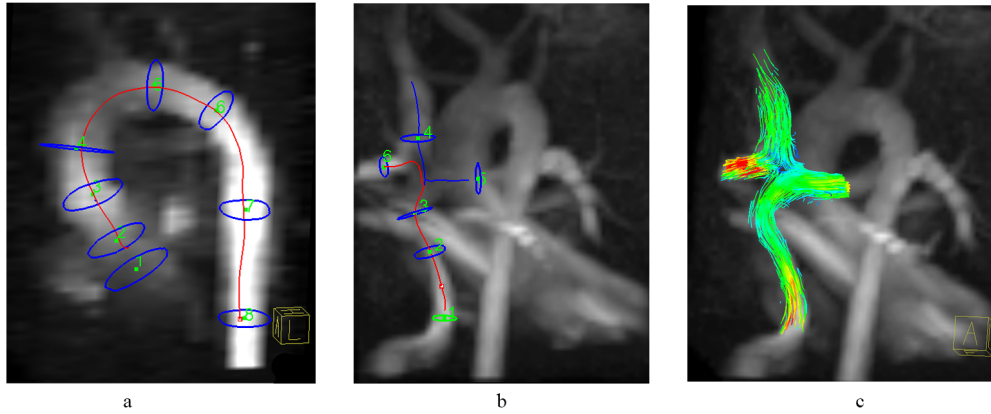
Cross-sections of 4D flow MRI data for the aorta (a) and TCPC (b), velocity streamlines in TCPC (c). For TCPC, cross-section 1 is located in the conduit or IVC, cross-sections 2, 3 are in the conduit, cross-section 4 is in the SVC, cross-section 5 is in the LPA, cross-section 6 is in the RPA.
